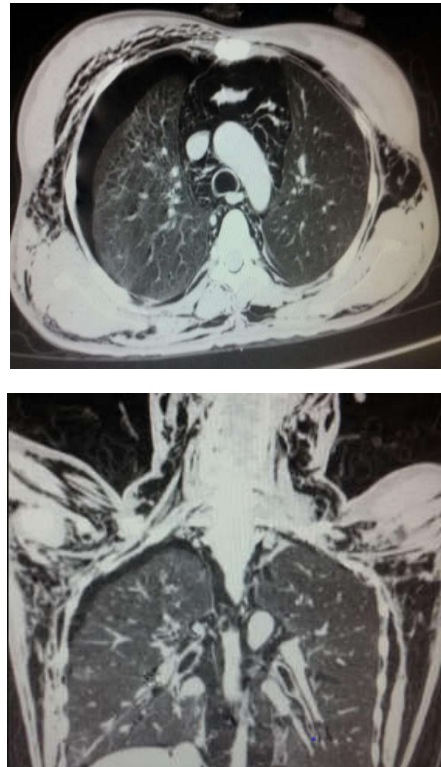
CT scan of the 2nd patient in axial section with coronal reconstruction: pneumomediastinum, pneumothorax and subcutaneous emphysema association.
